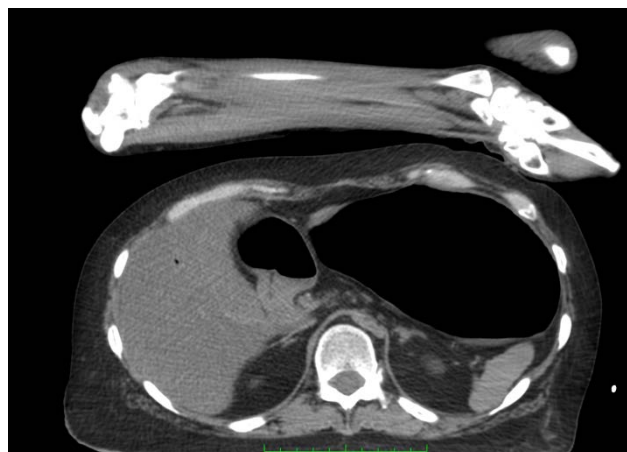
Example of upper extremity CT slice used for right radial artery measurement
